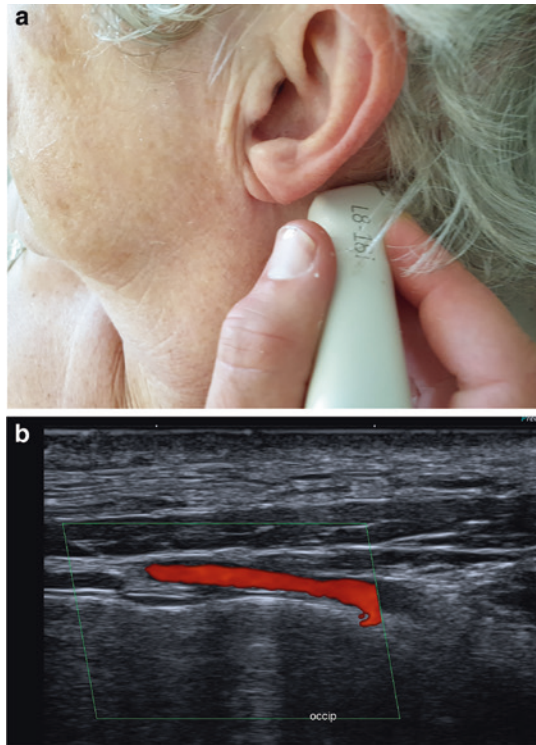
Examination of the occipital artery: a recommended position of the transducer b ultrasound image, longitudinal view
